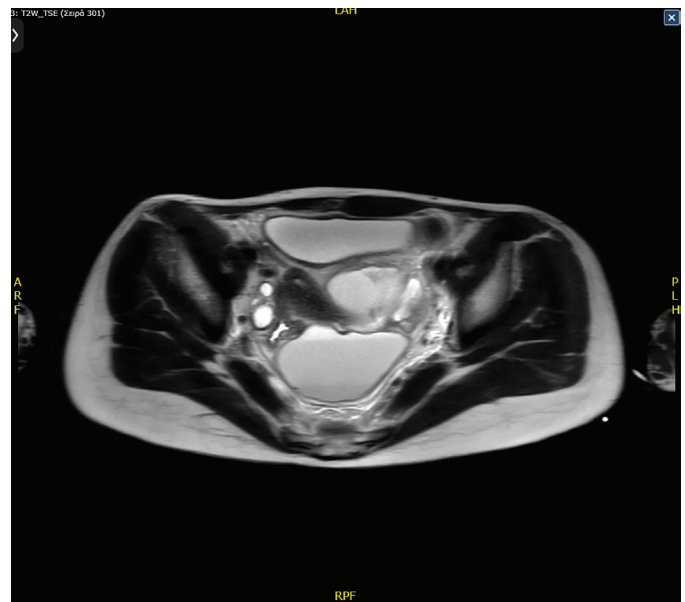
Axial T2-weighted pelvic magnetic resonance imaging obtained at the time of hospitalisation. The large multiloculated left adnexal mass is depicted with thickened walls and heterogeneous content consistent with Tubo-ovarian abscess. The bladder is visible anteriorly. The normal right ovary with preserved follicular morphology is identified in the right hemipelvis (contralateral side), providing comparison with the affected left adnexa.
